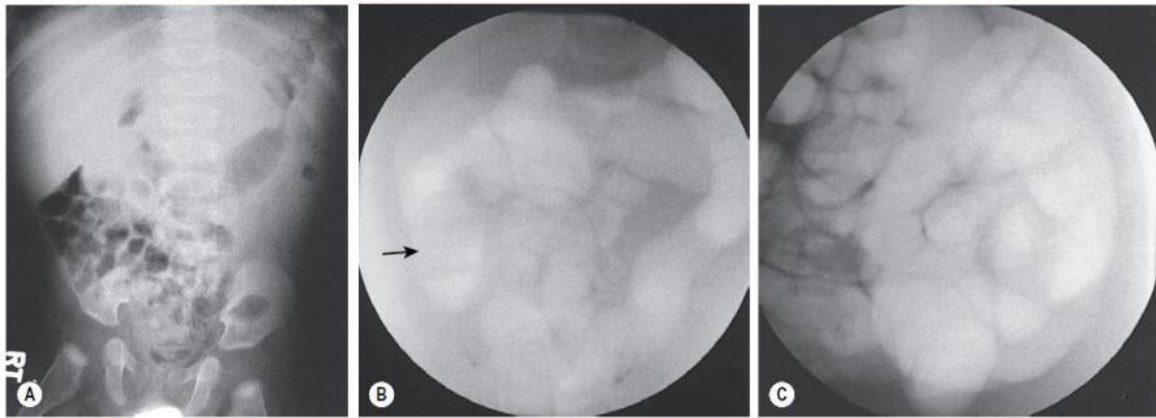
■ Plain radiography and fluoroscopic examination using air for pneumatic reduction of an intussusception. (A) Plain radiograph showing a mass effect in the right upper quadrant. (B) Pneumatic reduction to the vicinity of the cecum with the intussusception still present (arrow). (C) Complete reduction with reflux of air into multiple loops of small intestine. (Courtesy of Charles Maxfield, MD.)
